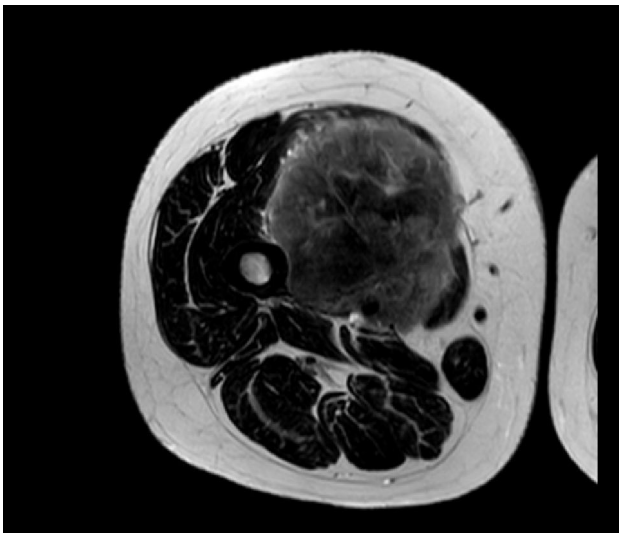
MRI axial T2WI showing large heterogenous mass involving the vastus medialis muscle in anteromedial aspect of right thigh; Note the tumor is completely encasing the adjacent femoral vessels and nerve and is closely applied to medial surface of femur with intact cortex.
